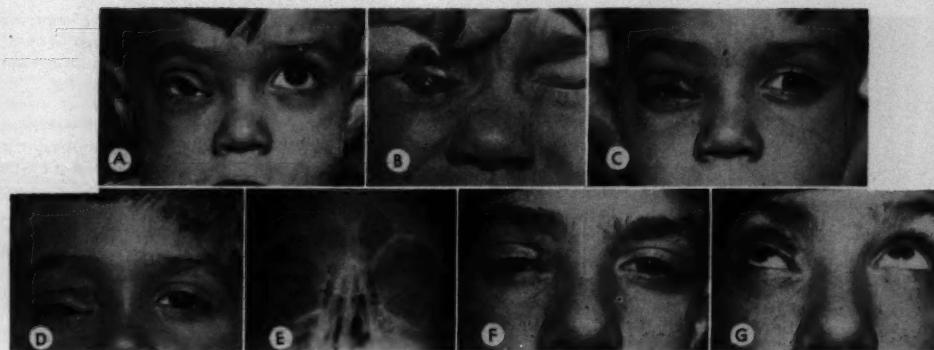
(Jones). Case 57. (A) Lymphangioma of orbit, upper lid, and fornix shown early in its development. (B) The upper lid everted to show tumor mass in fornix. (C) The same patient following sclerosing solutions and surgery. (D) The patient is shown later in his course, following further surgery. (E) X-ray films of the orbits show an increase in all dimensions on the right, with an occluded adjacent frontal cell and change in the bone at the upper inner orbital angle. (F) The patient is pictured as he appeared following recent partial excision and plastic repair. (G) This is a second view taken recently to show that the ptosis is decreasing.
